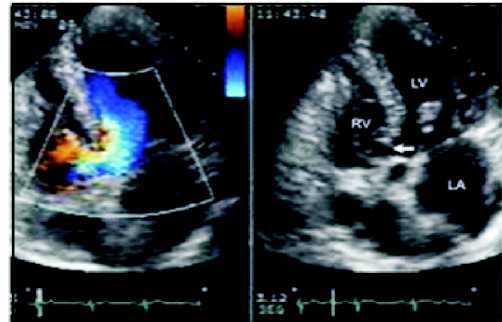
2D Echocardiogram showing large perimembranous VSD with MVP.
